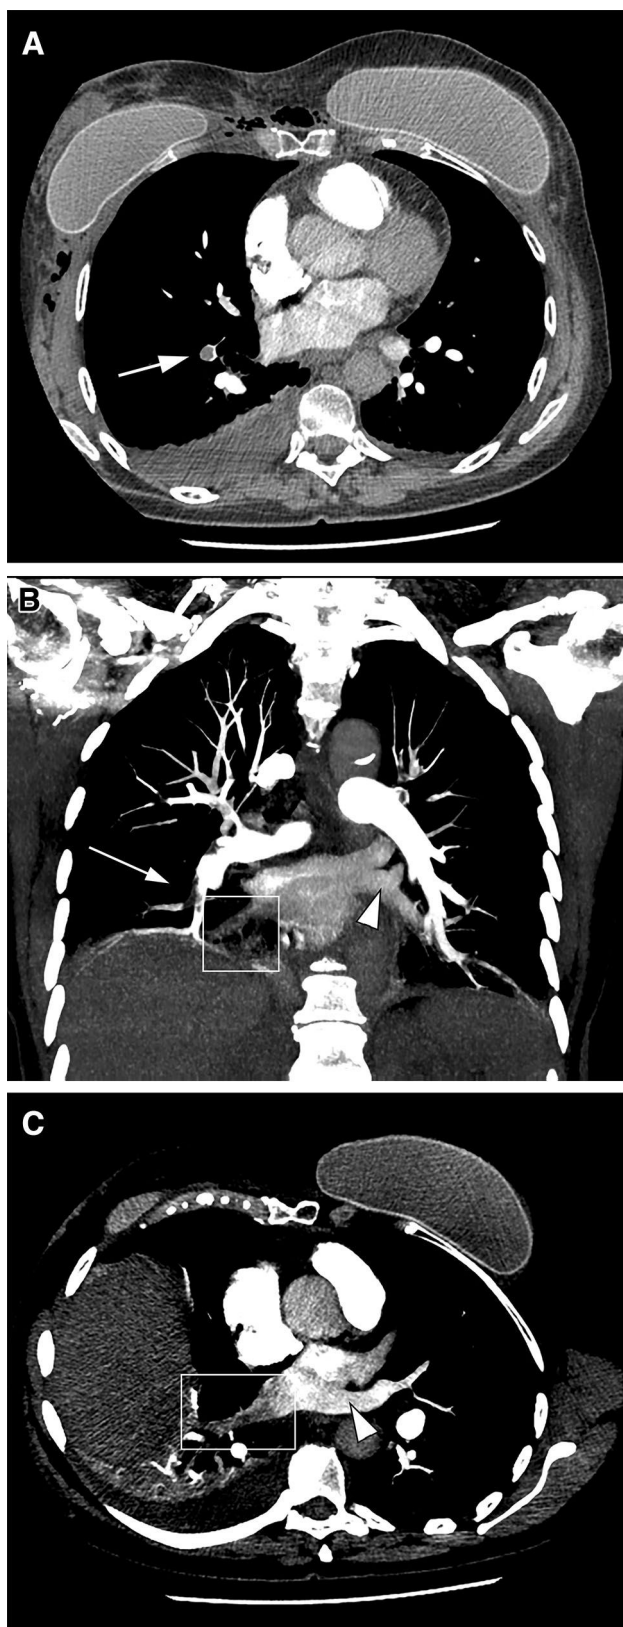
Images from a 46-year-old woman on the seventh post-operative day after bilateral breast augmentation surgery, with history of mastectomy due to breast cancer. Patient presented at the emergency department with sudden chest pain and dyspnea. Axial (a) and coronal (b) computed tomography images demonstrating a filling defect on a segmental pulmonary artery of the right lower lobe (white arrow). A filling defect greater than 2 cm is also noted in the adjacent pulmonary vein on the coronal (b) and oblique (c) CT reconstructions (white square), characterizing the “pulmonary vein sign.” Comparatively, the other pulmonary veins are normally filled with contrast media (white arrowhead)
